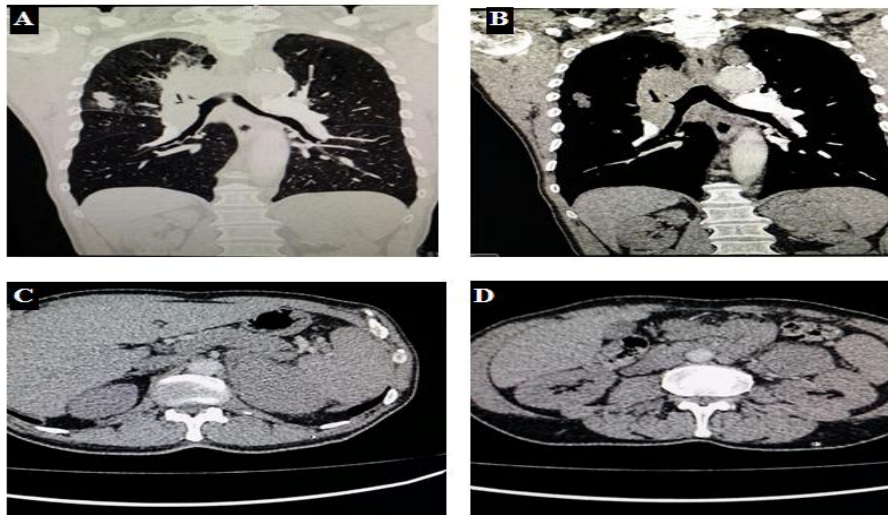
Male patient 75 years old, complaint: dyspnea and cough, normal laboratory tests, chest CT with contrast administration coronal A) lung and B) mediastinal windows, Two, small spiculated pulmonary nodules at right upper lobe, another large one noted abutting the superior mediastinum multiple mediastinal lymphadenopathy, (C&D) axial scan of upper abdominal: large well defined, heterogeneous left adrenal mass with RPW 25% consistent with metastases and proved by biopsy (metastases of bronchogenic carcinoma).
